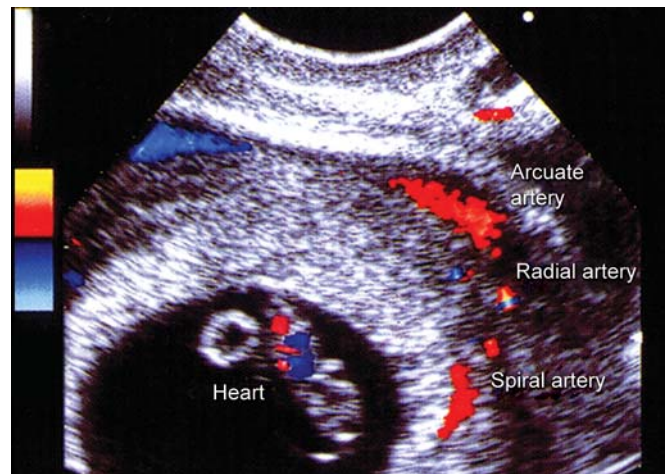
Image recorded by 2D color Doppler sonography showing blood flow in part of uteroplacental circulation (arcuate, radial and spiral arteries). The terminal segments of spiral arteries will be remodeled by trophoblast cell invasion
